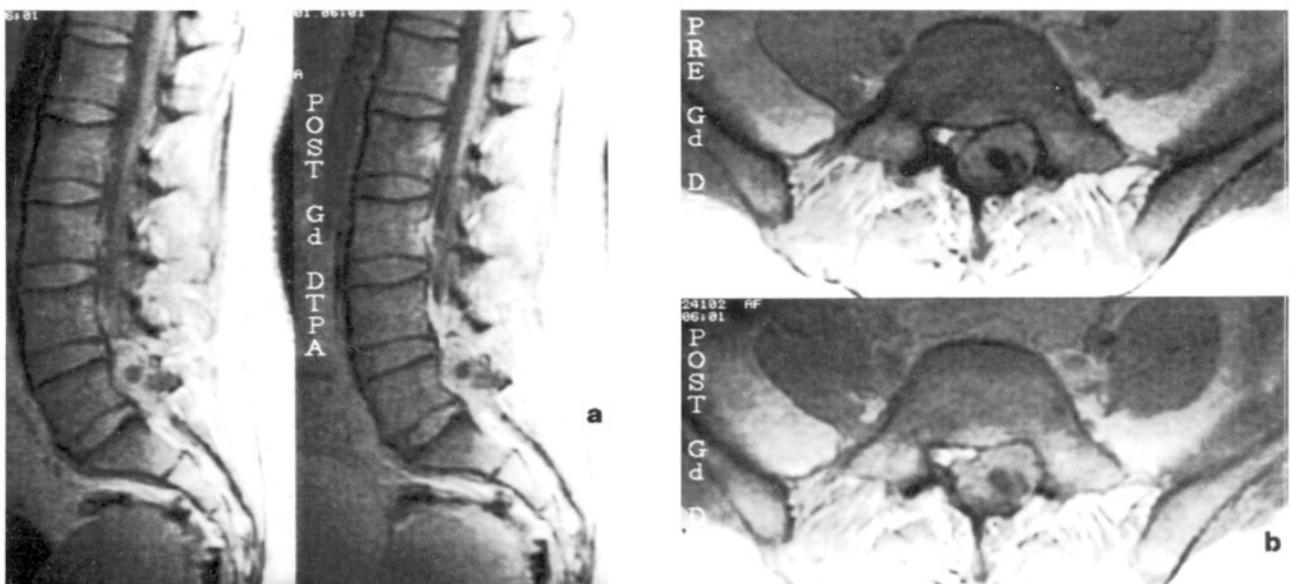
a and b. Pre-contrast and post-contrast sagittal (a) and axial (b) T1-weighted spinal MRI scans showing L5 and S1 mass lesion obliterating the epidural space and causing erosion of laminae and pedicles on the left side. The mass is composed of multiple hypointense areas and a wide isointense mass surrounding it.
